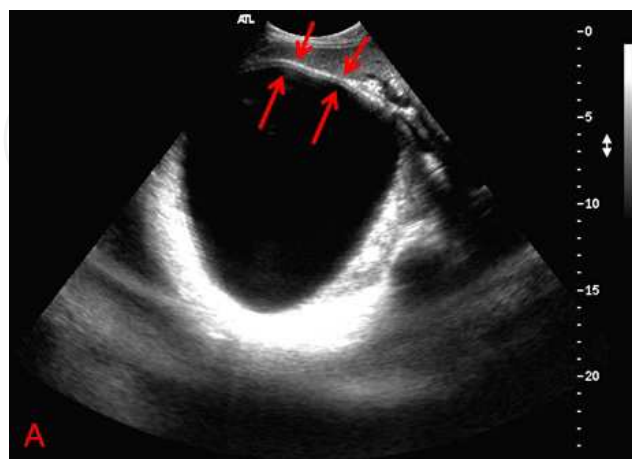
A: B-mode ultrasonography demonstrating an anechoic, smooth cyst located at the right lobe of the liver: Cyst Hydatid (Gharbi type 1, WHO; CE 1). The cyst wall manifests as double echogenic lines separated by a hypoechogenic layer (arrows).
